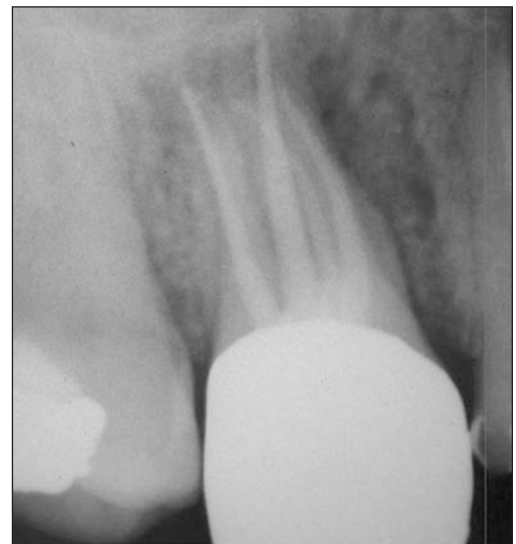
A radiograph of a well-obturated upper molar.
